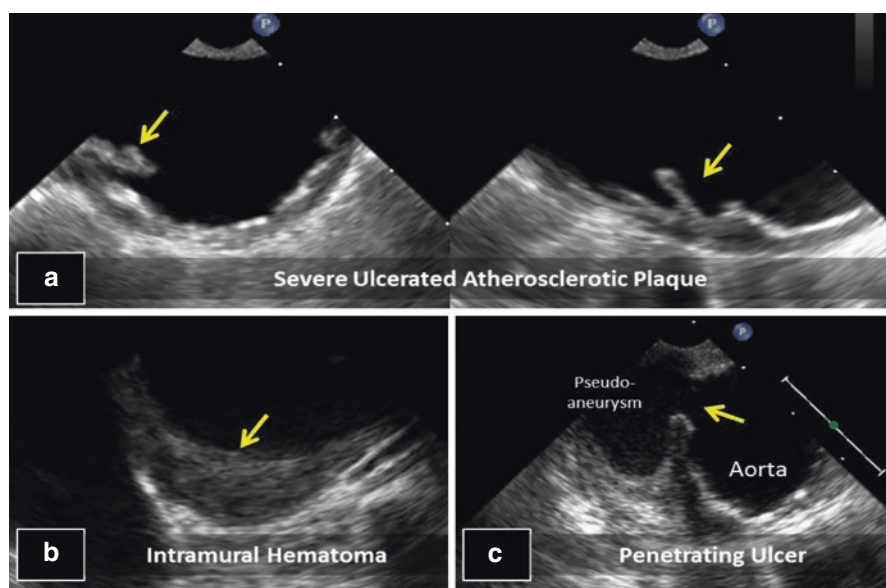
Atheroma triad. (a) Severe ulcerated atherosclerotic plaque in the aorta visualized in multiple planes on transesophageal echocardiogram. (b) Intramural hematoma in the wall of the aorta due to rupture of vasa vasorum. (c) Penetrating ulcer in the aorta leading to creation of pseudoaneurysm outpouching
